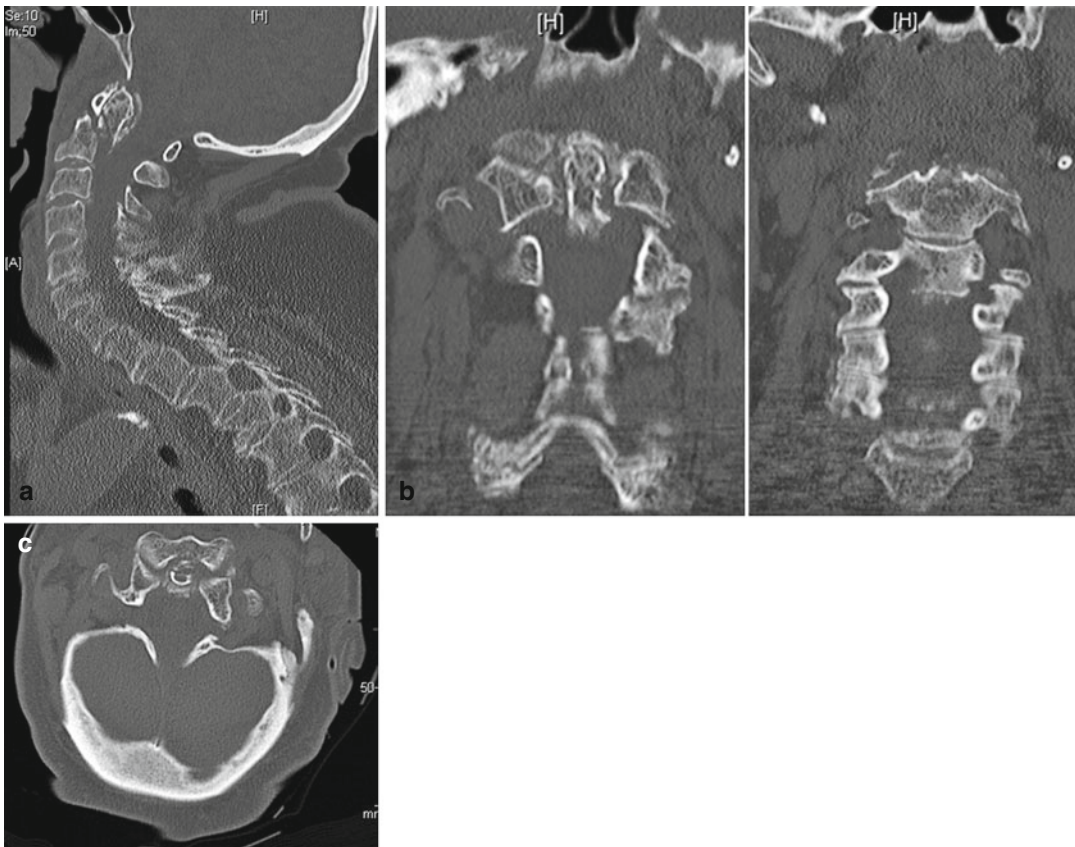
CT scan of the cervical spine demonstrating a Type IIC odontoid fracture
